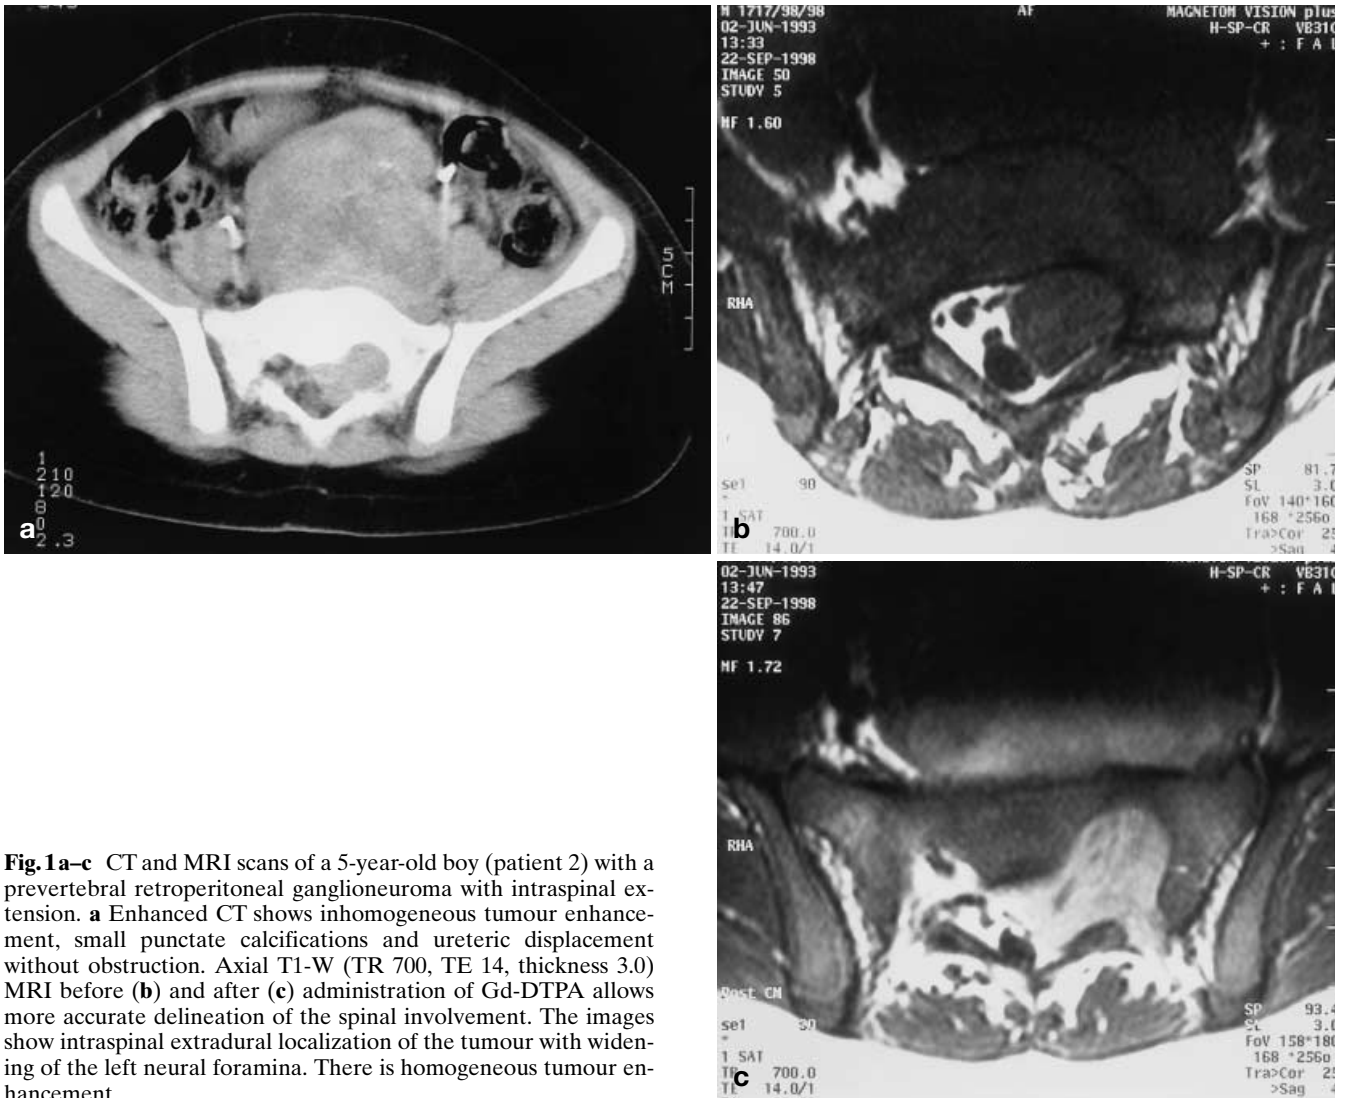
CT and MRI scans of a 5-year-old boy (patient 2) with a prevertebral retroperitoneal ganglioneuroma with intraspinal extension. a Enhanced CT shows inhomogeneous tumour enhancement, small punctate calcifications and ureteric displacement without obstruction. Axial T1-W (TR 700, TE 14, thickness 3.0) MRI before (b) and after (c) administration of Gd-DTPA allows more accurate delineation of the spinal involvement. The images show intraspinal extradural localization of the tumour with widening of the left neural foramina. There is homogeneous tumour enhancement
